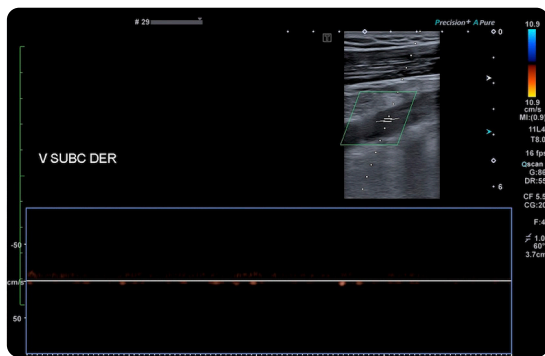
Doppler ultrasound of venous vessels of the right upper limb. Dilatation and occupation by echogenic material within the subclavian vein, extending to the right axillary vein with absence of flow after color and spectral Doppler scanning.
